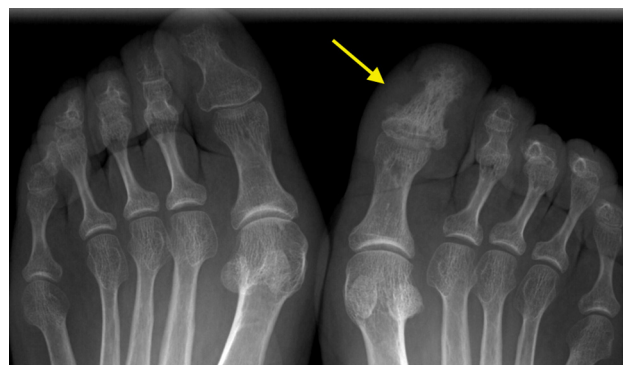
Anteroposterior radiographs of both feet. The distal phalanx of the great toe of the right foot shows global sclerosis with the appearance of “ivory” (arrow).
